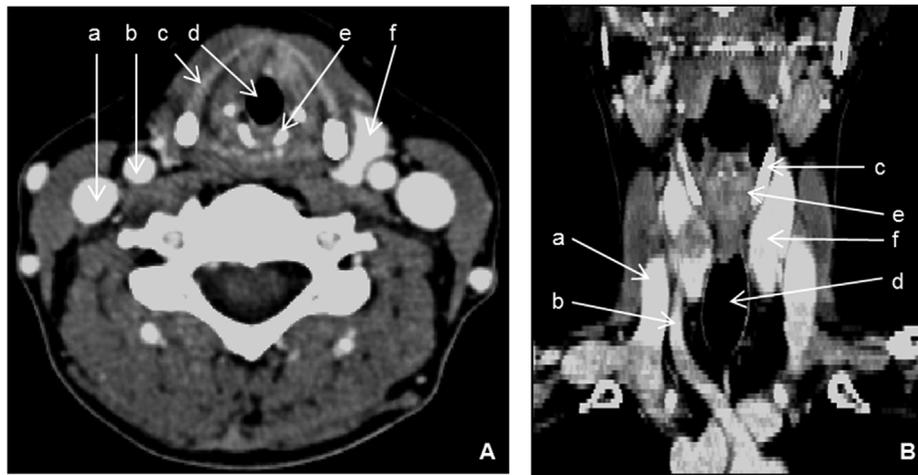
Thyroid anatomy using head and neck CT. (a) Internal jugular vein, (b) common carotid artery, (c) thyroid cartilage, (d) trachea, (e) cricoid cartilage, and (f) thyroid.
